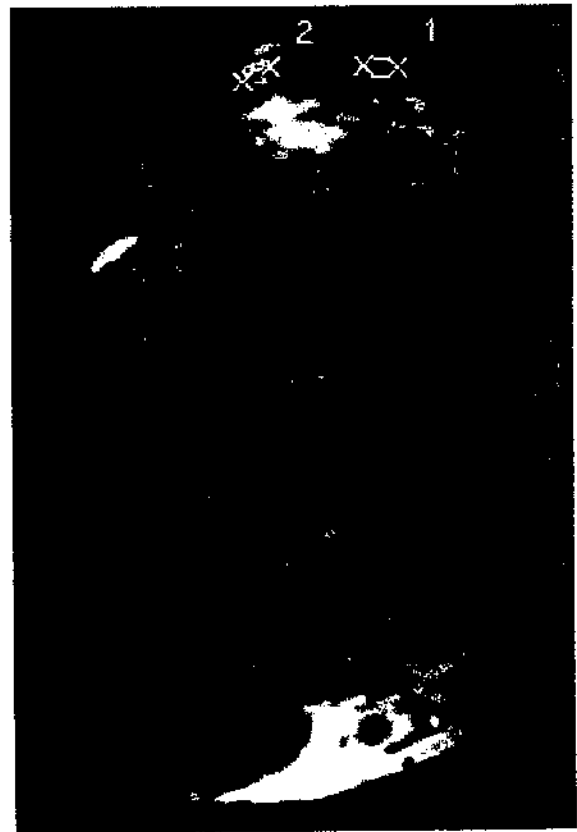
Magnetic resonance imaging scan of the knee in the axial plane. Top, a 7-mm central slit in the central part of the patellar tendon. Bottom, two 5-mm slits after reharvesting of a free patellar tendon graft.
